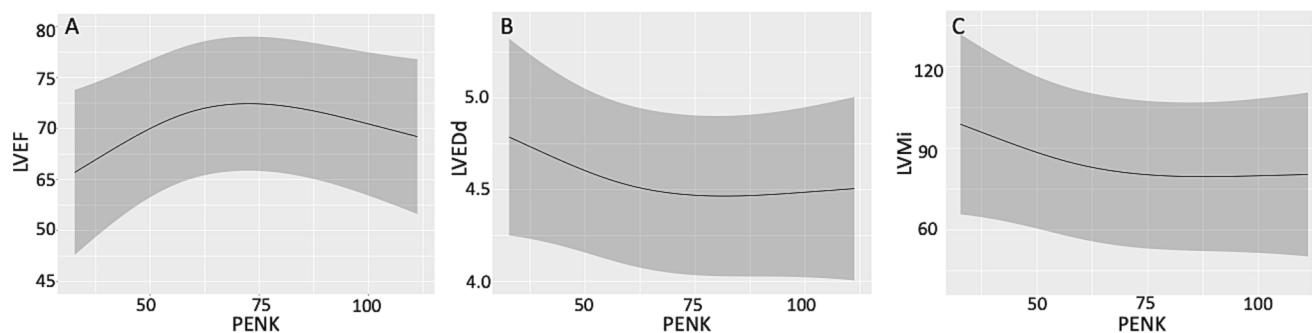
Estimated echocardiographic measurements and 95% confidence intervals for PENK values modeled as restricted cubic spline in the fully adjusted linear regression models. There was a significant non-linear association between PENK and LVEF, with LVEF having an inverted U-shaped relationship with PENK (A). There were no significant non-linear relationships between PENK and LVEDd and LVMi (B and C).
